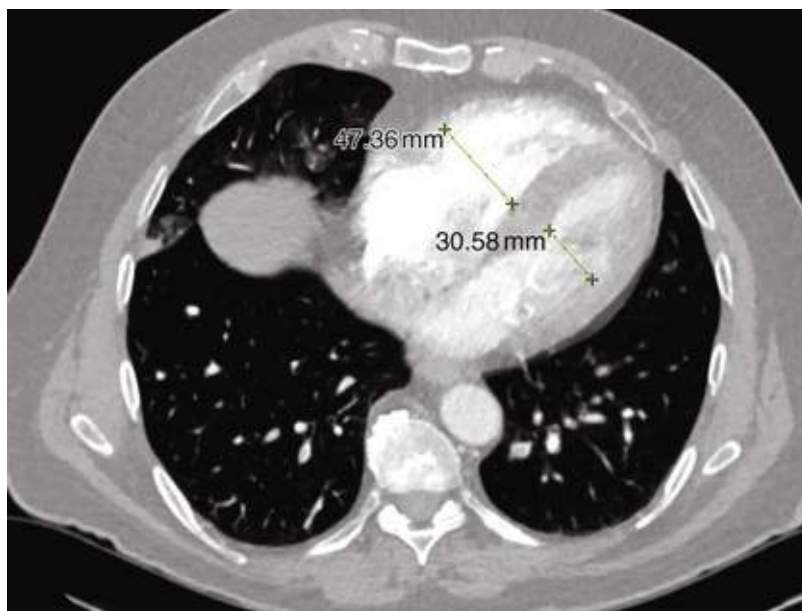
Enlarged right ventricle on chest CT in a patient with PE. Normally, the ratio of the diameters of the right ventricle and the left ventricle is less than 0.9. This patient has an RV diameter of 47 mm and an LV diameter of 31 mm. The RV/LV diameter ratio of 1.5 is abnormally high. LV, left ventricular; RV, right ventricular.
